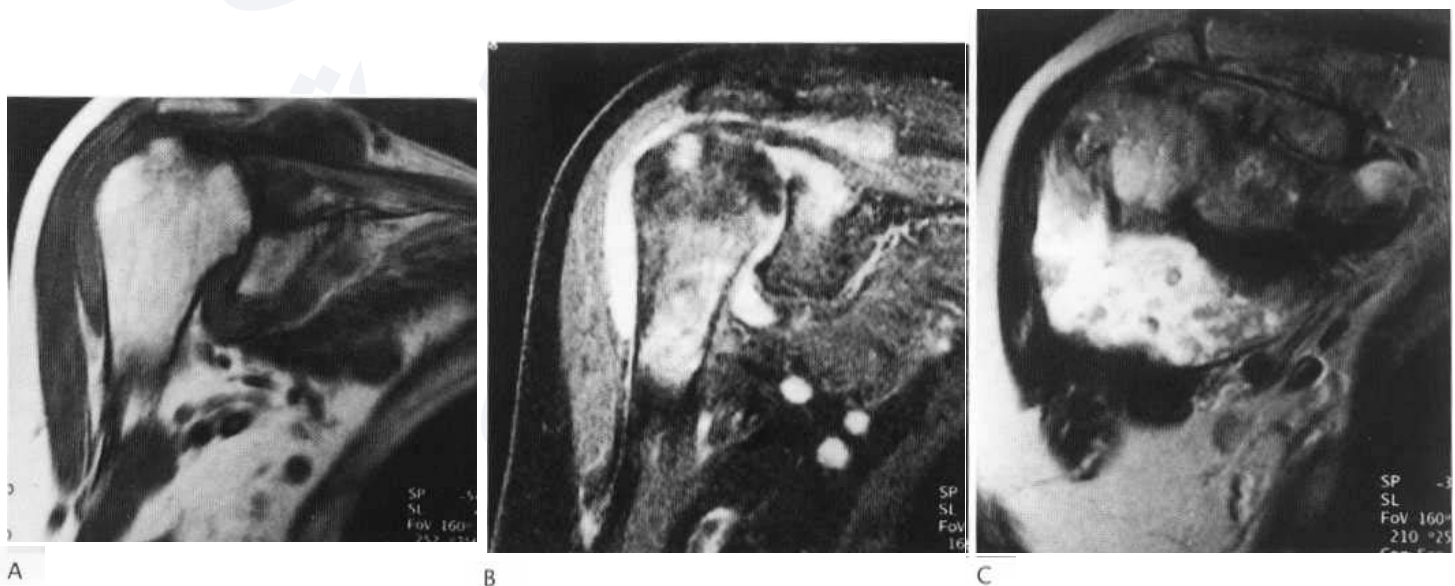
Rheumatoid arthritis at MRI. (A) Coronal T₁-weighted sequence. (B) Coronal fat-suppression images. There is a large effusion in the shoulder joint and in the subacromial bursa. There is upward subluxation of the humeral head but the rotator cuff tendon is in part intact. Erosive changes are demonstrated in the humeral head with the appropriate signal change. (C) A more anterior scan shows the distended subacromial bursa containing numerous loose bodies. See also Fig. 38.19.
